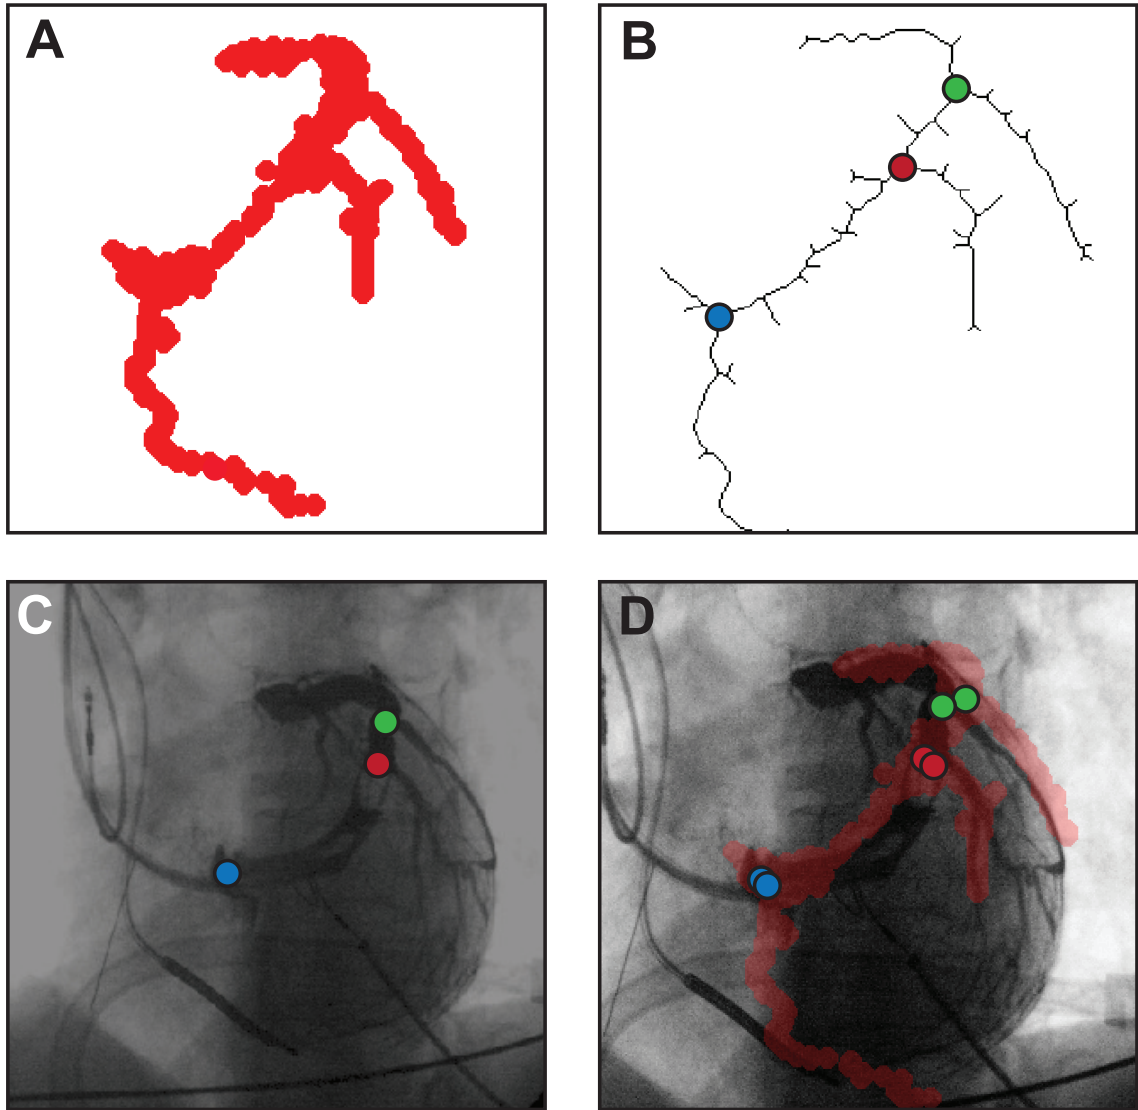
The reconstructed MRCV geometry is projected onto the venogram image plane as a binary mask and dilated to create a single entity (A). The dilated mask is then skeletonized to assist in identifying branch points (B). By selecting corresponding branch points in the skeleton (B) and venogram (C), the venogram can be calibrated to correspond to the MR imaging coordinates (D).
